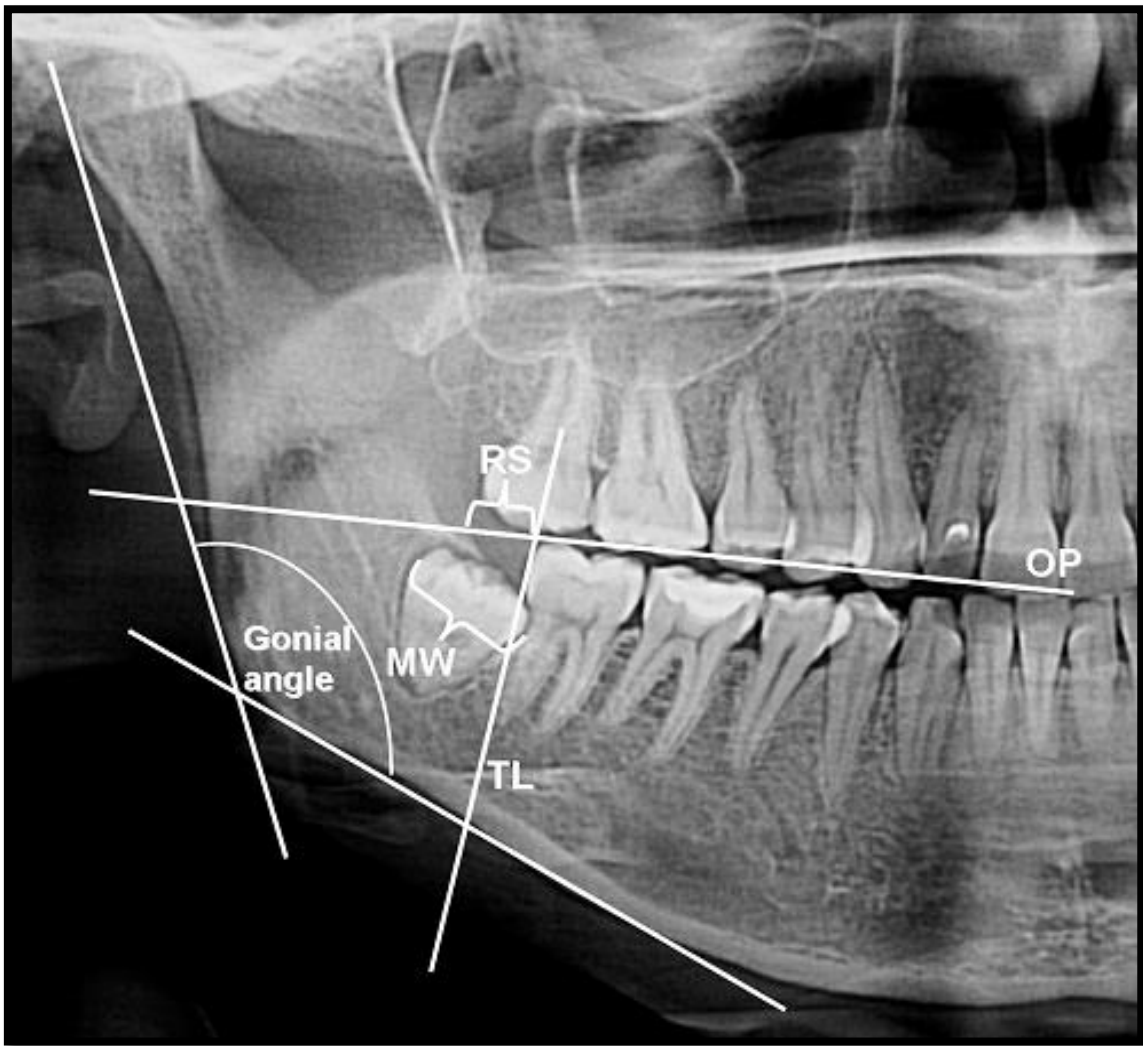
Linear and angular measurements on orthopantomogram radiograph
